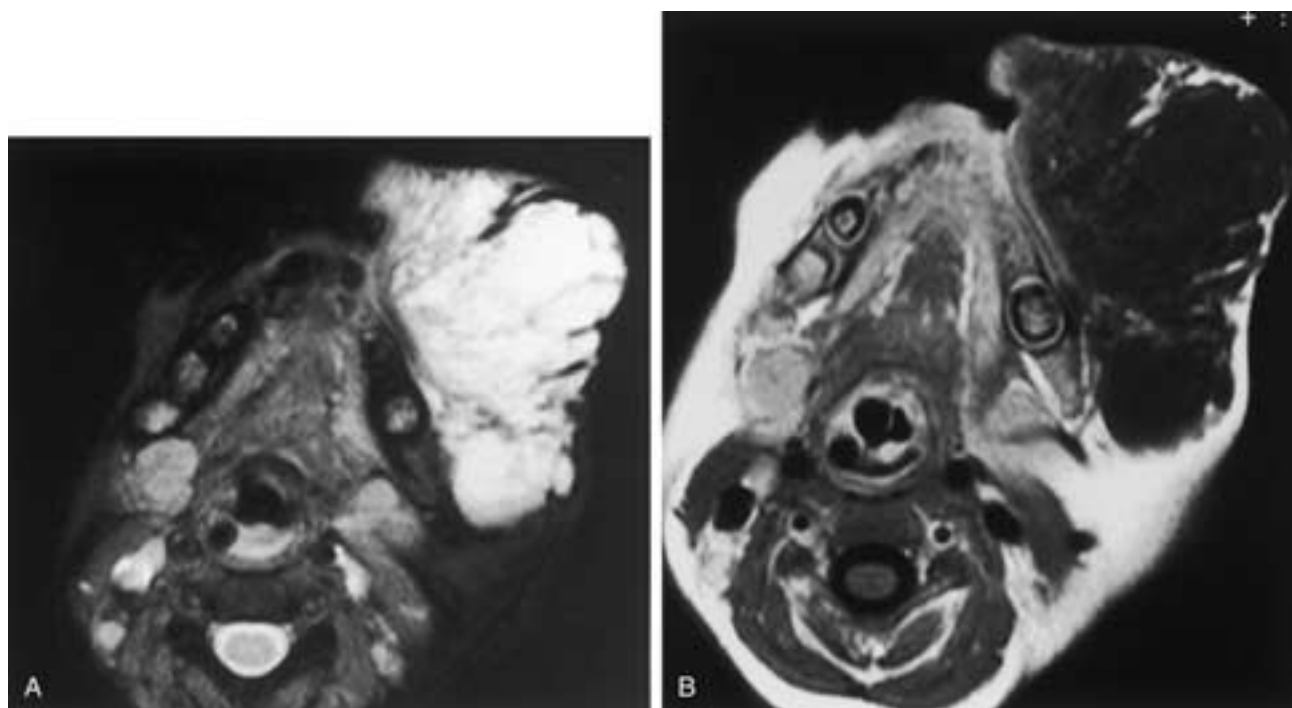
Lymphangioma. Axial T2-weighted (A) and T1-weighted (B) images following contrast enhancement. These images demonstrate a large subcutaneous lymphangioma involving the left buccal region. The lesion is isointense to muscle on the T1-weighted image (B), is markedly hyperintense on the T2-weighted image (A), and demonstrates no enhancement following contrast administration.
